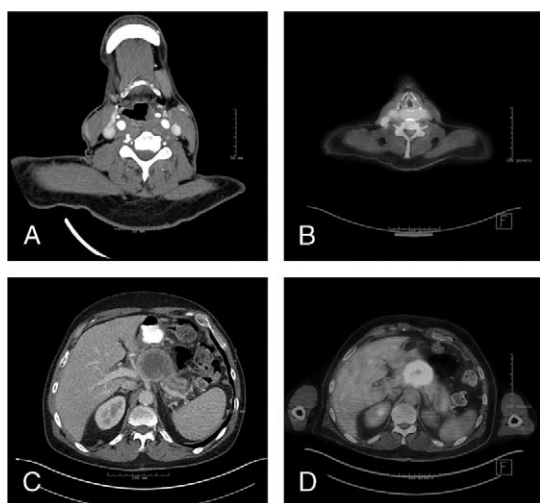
Neck CT (A) and PET/CT (B) imaging demonstrates an asymmetric, hypermetabolic soft tissue mass in the left pyriform sinus, extending toward the post cricoid region. C, A heterogeneous large mass in the upper abdomen with distal pancreatic atrophy and mild ductal dilatation is shown in abdominal CT. D, Abdominal PET/CT reveals a hypermetabolic mass in the celiac-axis region concerning for neoplastic process.
